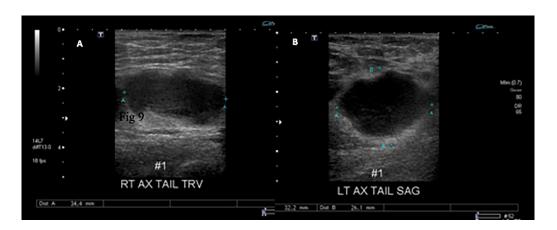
(Patient no. 2): Ultrasound of right axilla (A) and left axilla (B), both show enlarged, rounded, hypoechoic lymph nodes with gently lobulated margins and complete loss of fatty hila, indicating disease infiltration.
